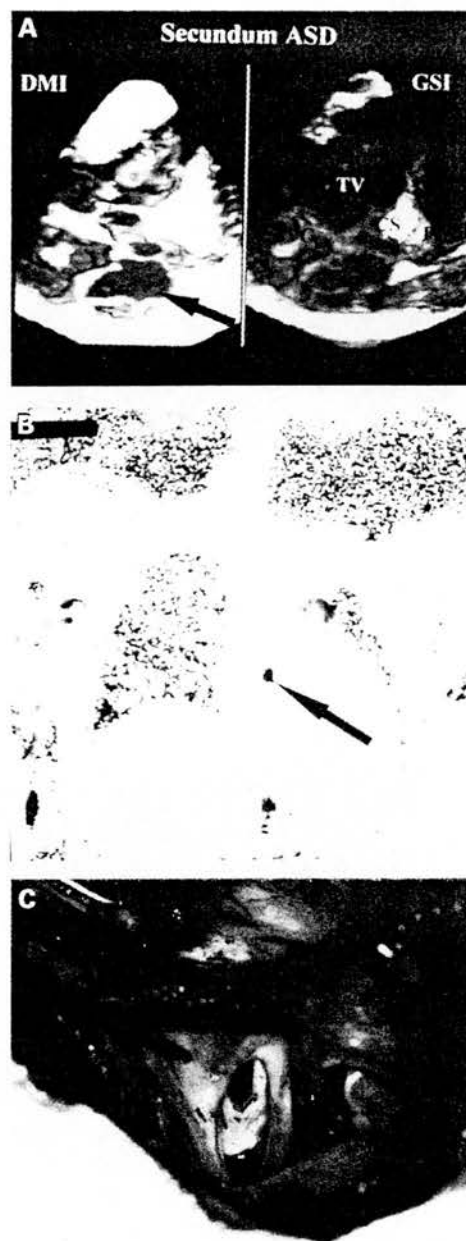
Maximum orifice of an atrial septal defect (ASD) as defined by three dimensional echocardiography (A), phase contrast cine magnetic resonance imaging (B), and surgery (C). CS, coronary sinus; DMI, Doppler myocardial imaging; GSI, grey scale imaging; IVC, inferior vena cava; SVC, superior vena cava; TV, tricuspid valve.
